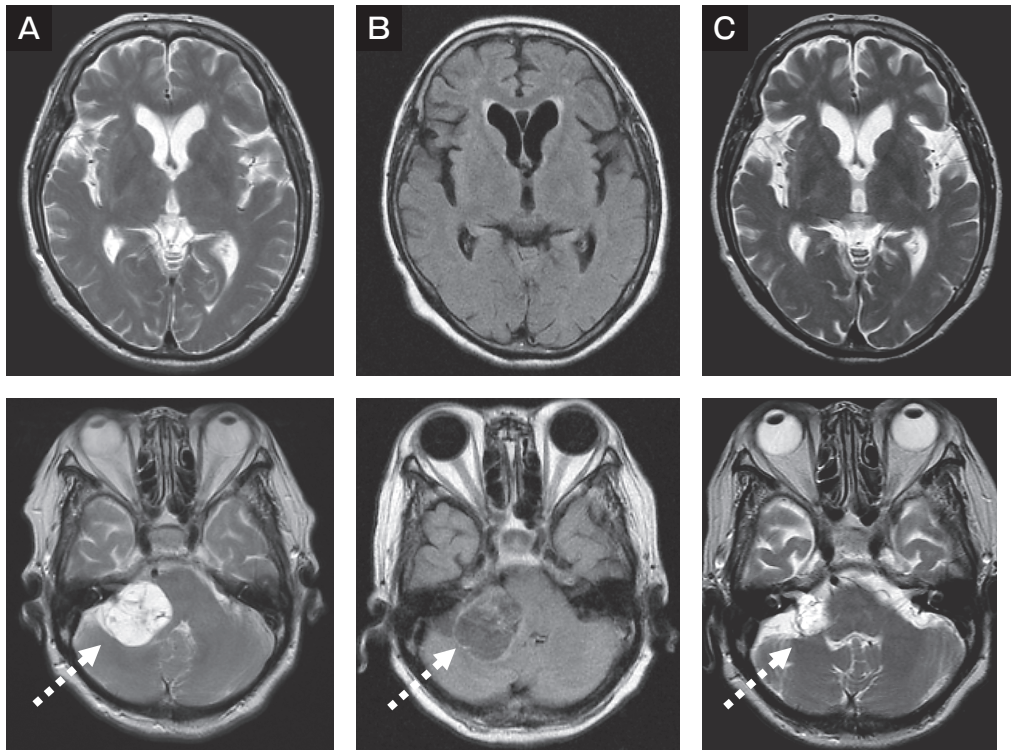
Axial views of T2-weighted images and fluid attenuated inversion recovery (FLAIR) images. The arrowhead demonstrates the tumor. A, T2-weighted images taken prior to Gamma Knife radiosurgery (GKS); B, FLAIR images taken 6 months after GKS. Hydrocephalus had not developed; C, T2-weighted images 60 months after GKS. Shrinkage of the tumor was obvious.
